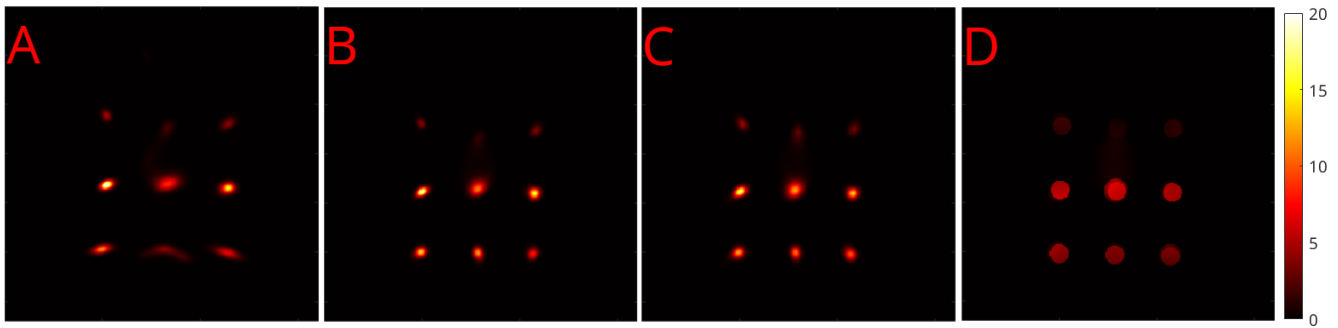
SPECT image reconstruction was driven by the simultaneous MRI acquisition. (A) SPECT acquisition acquired from a single scan of the INSERT system. (B) The reconstruction uses two acquisition positions to cover the detector gap and recover the resolution at the bottom of the image with 25 angles. (C) The SPECT reconstruction can use additional detector positions to acquire 30 detector angles, and the SPECT to MRI transformation registers all data in one space. (D) The MRI data provides anatomical prior to carrying out the MAP-EM reconstruction.
